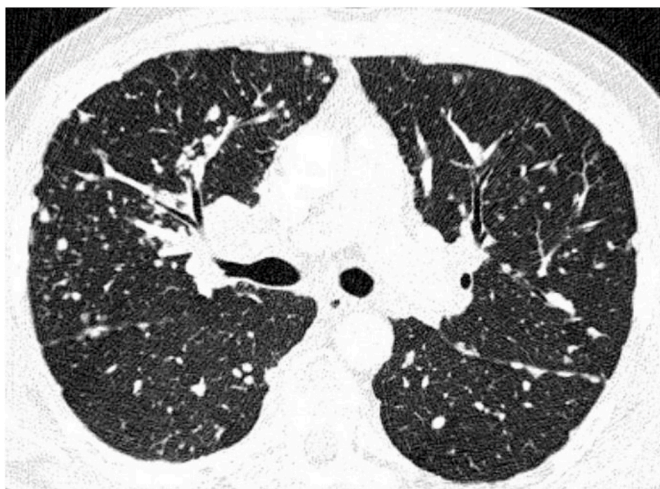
Computed tomography scan showing multiple lung and subpleural nodules in a perilymphatic distribution in both upper lobes.
